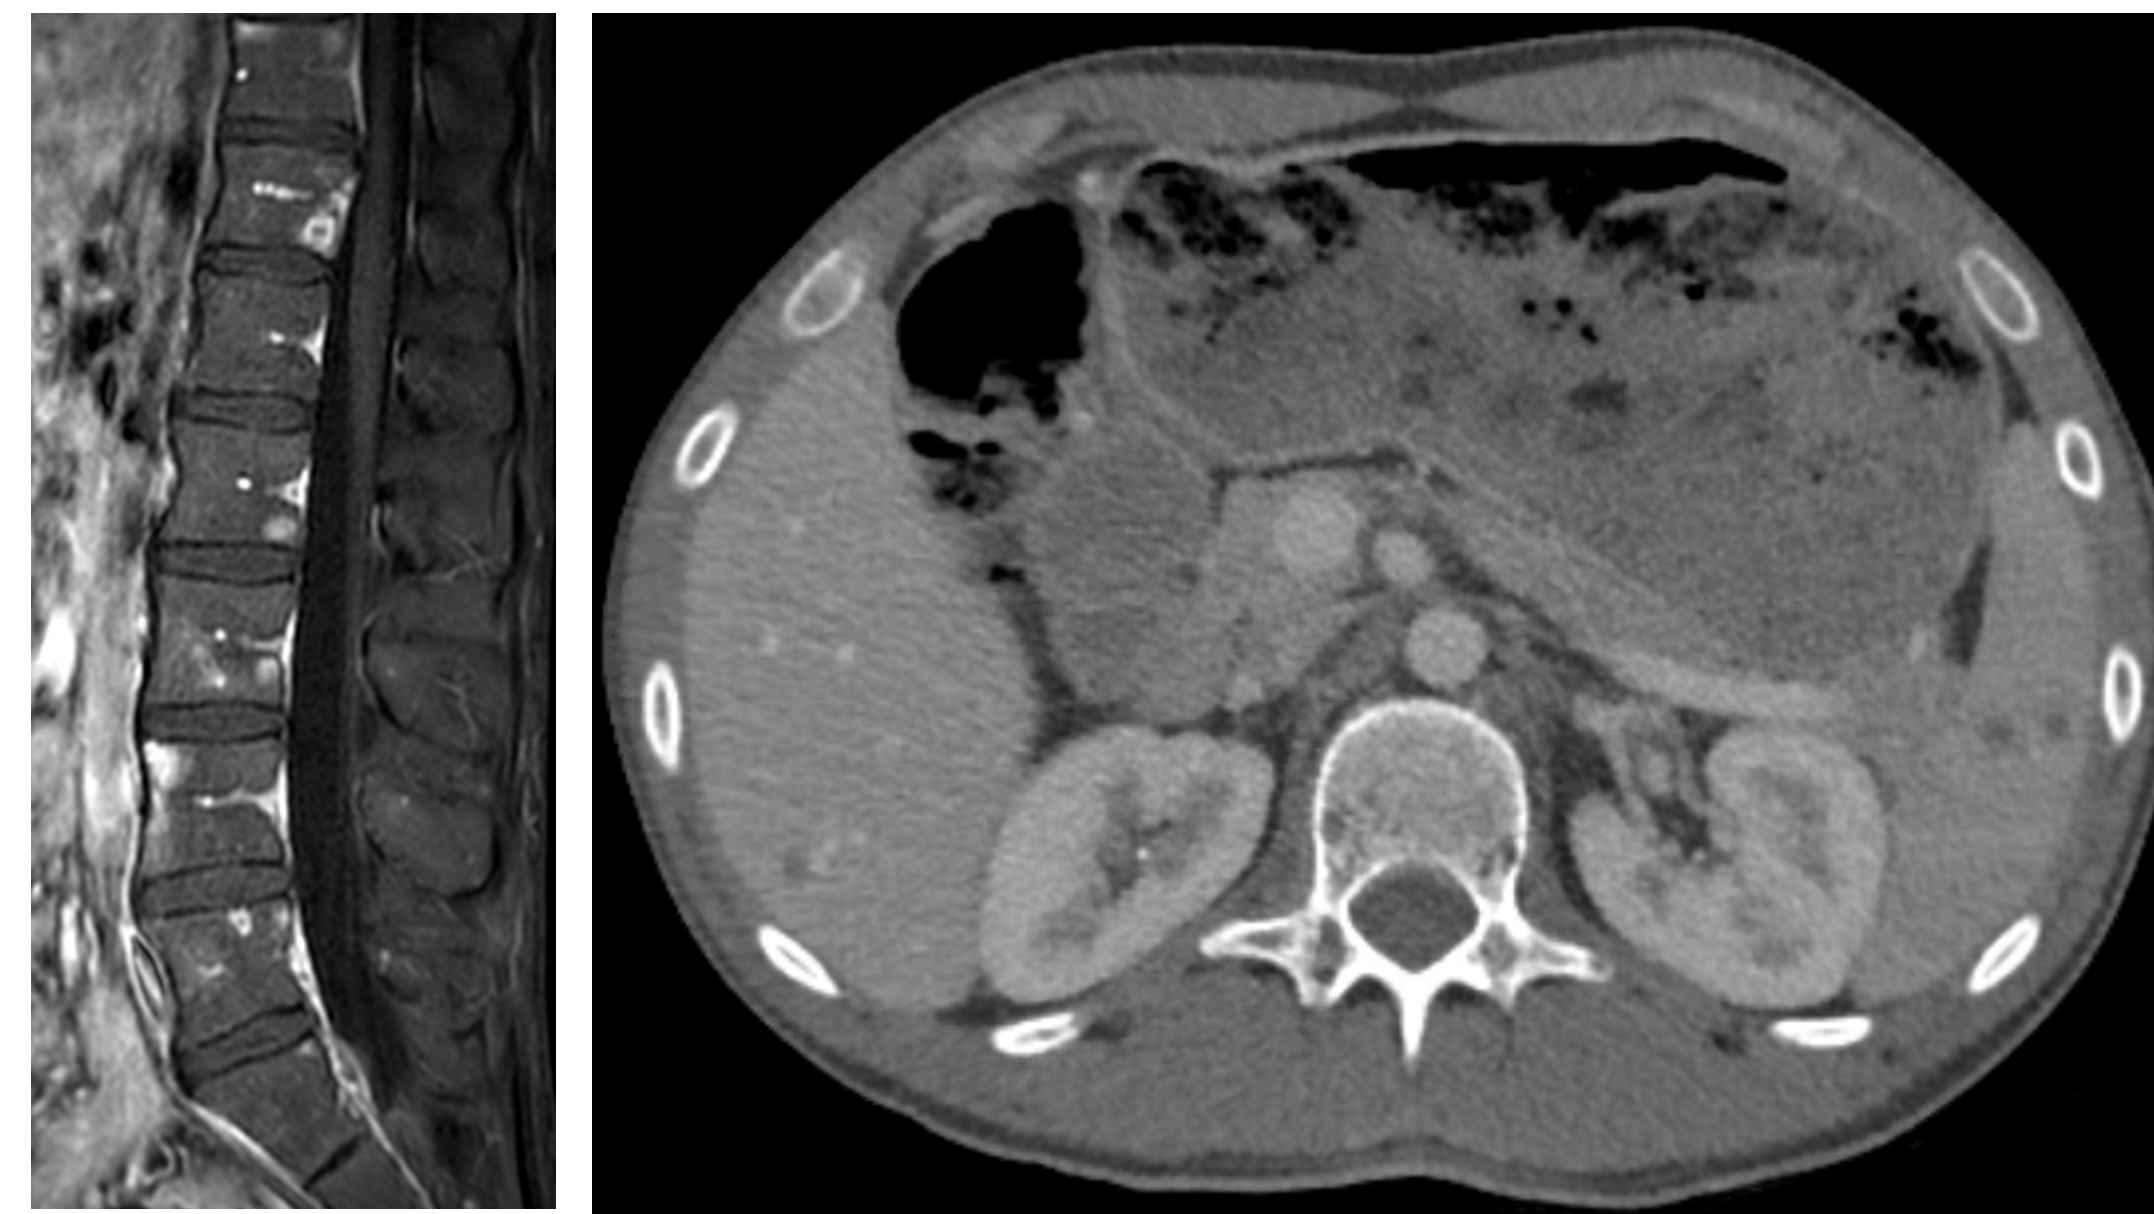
MRI with contrast (left) of lytic bone lesions; CT with contrast (right) showing liver and splenic hypodensities
